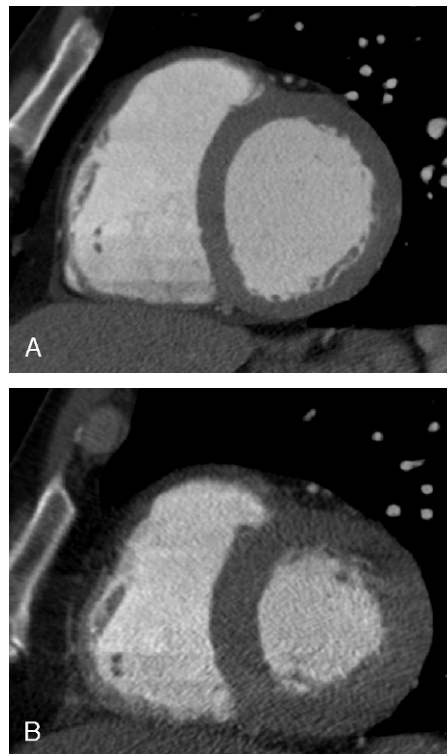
A, High resolution image obtained with high tube current during end-diastole (85% of the cardiac cycle). The contrast-to-noise ratio is high and there is little background noise, allowing for accurate depiction of the coronary arteries, plaque composition and wall motion, and mass and volumes. B, Lower resolution obtained during tube modulation, when the tube current is reduced. While there is increased noise on the image, it is still very adequate for evaluation of wall motion, LV mass and volumes of chambers (40% of the cardiac cycle). Thus, use of dose modulation should still allow accurate depiction of EF and volumes, while reducing radiation dose of the cardiac CT evaluations.
